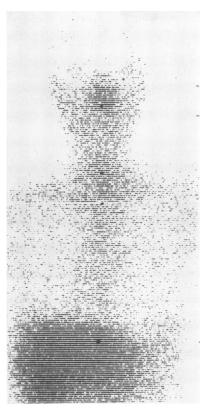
Normal <sup>67</sup>Ga-scintigram of the chest (anteroposterior view). Uptake in liver and breastbone are normal findings.
